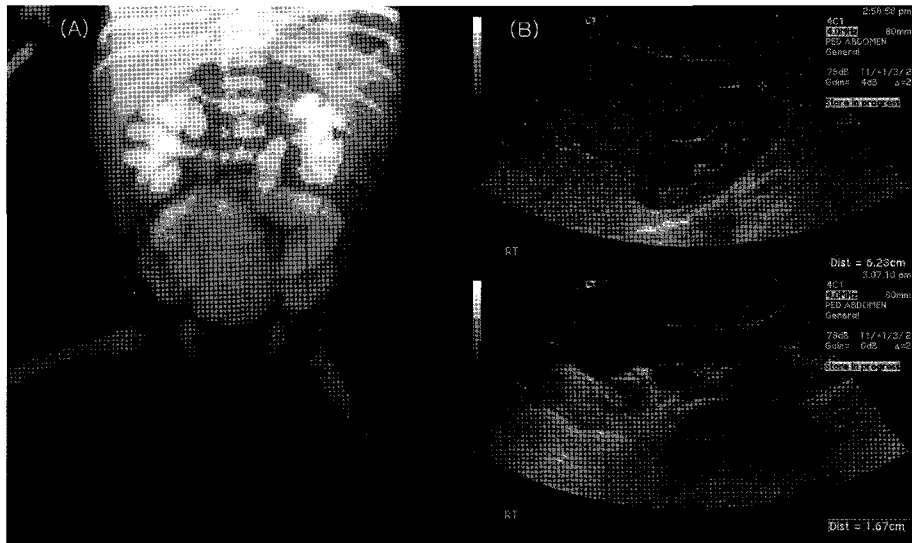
IVU and renal ultrasonography show dilated renal calyces with faceted contours and bullous dilatation of ureters, especially distal portion. There is no remarkable dilation of both renal pelvises.
